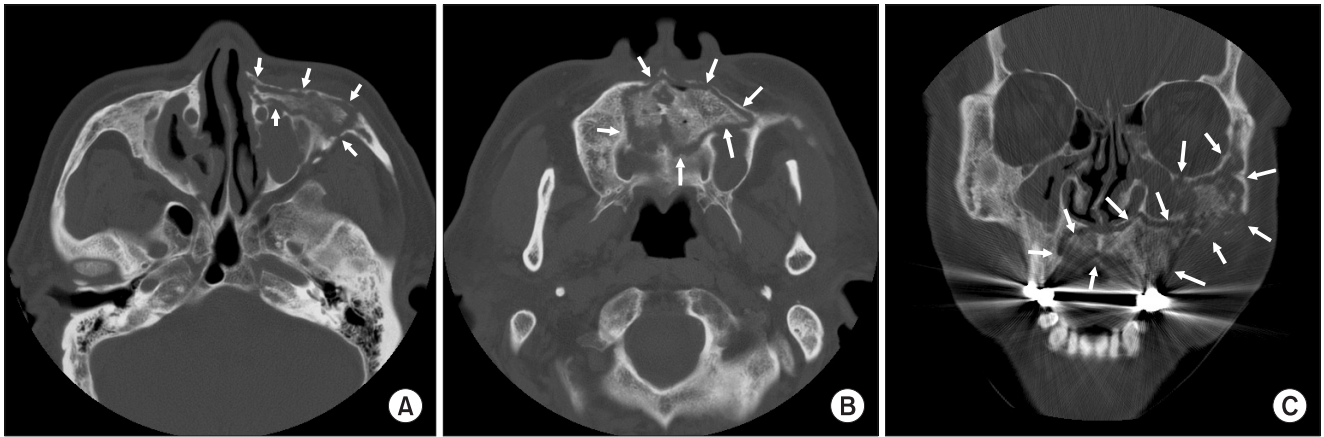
A. Preoperation computed tomography (CT) axial view: presenting involvement of left maxilla, zygoma and severe mucosal thickening on both maxillary sinus. B. Preoperation CT axial view: presenting involvement of maxilla, left maxillary sinus; and increased bony sclerosis in the medullary portion of left maxilla. C. Preoperation CT frontal view: presenting involvement of left maxilla, zygoma, floor of orbit, ethmoidal, sphenoidal sinus, nasal cavity, alveolar bone. Arrows indicate the border of the lesion.
